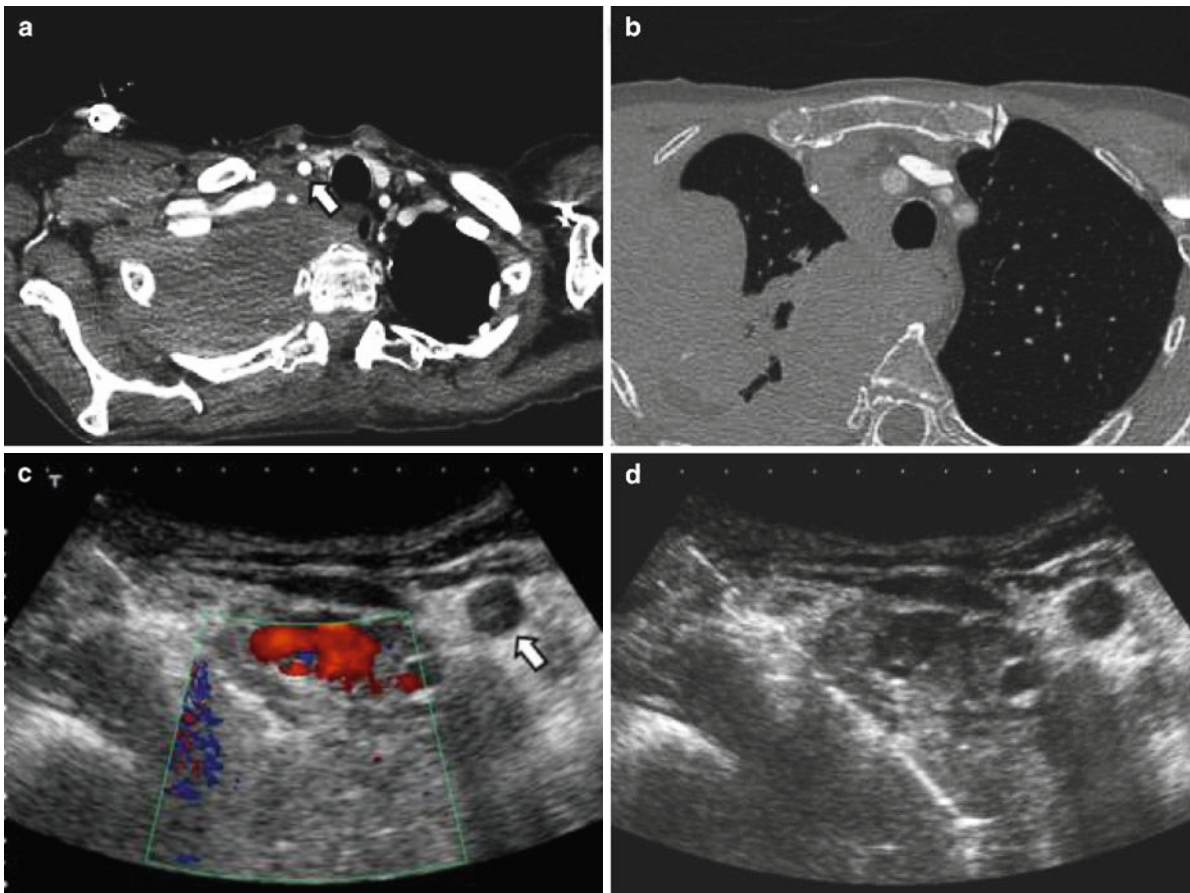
Ultrasound-guided biopsy in a 65-year-old patient with lymphoma. Ultrasonography allowed real-time control of needle progression near the right subclavian vessel (in red with color
